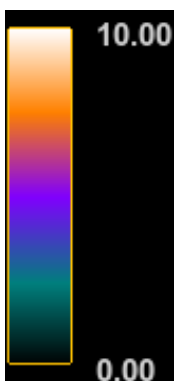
The legend that is in every axial fused PET/CT to display the intensity of the uptake in form of SUVmax in different colors.
